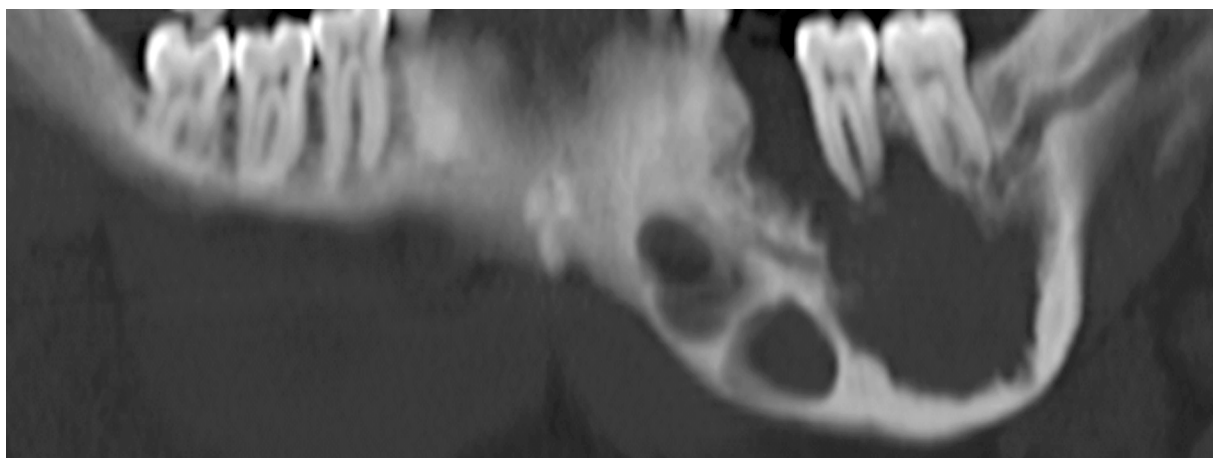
Ameloblastoma on reformatted panoramic CT showing remarkable expansion in the vertical plane.
